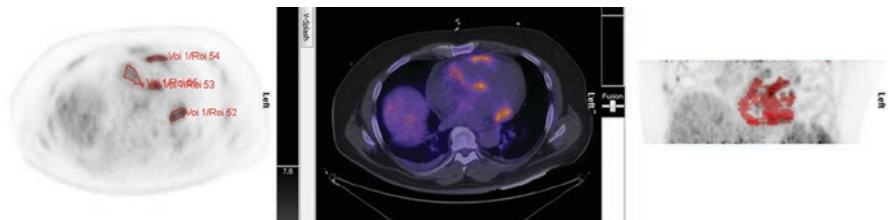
Quantitation of volume of inflamed myocardium. Relative FDG imaging is not adequate for evaluation of response to therapy. For this reason, quantitation of FDG uptake using standardized uptake values (SUV) or volume of inflamed myocardium is important. The volume of inflamed myocardium on the cardiac FDG images of the patient from Fig. 10.1, using an SUV_{max} threshold of 2.7 as 138 cm^3 . *FDG* ^{18}F -fluorodeoxyglucose
